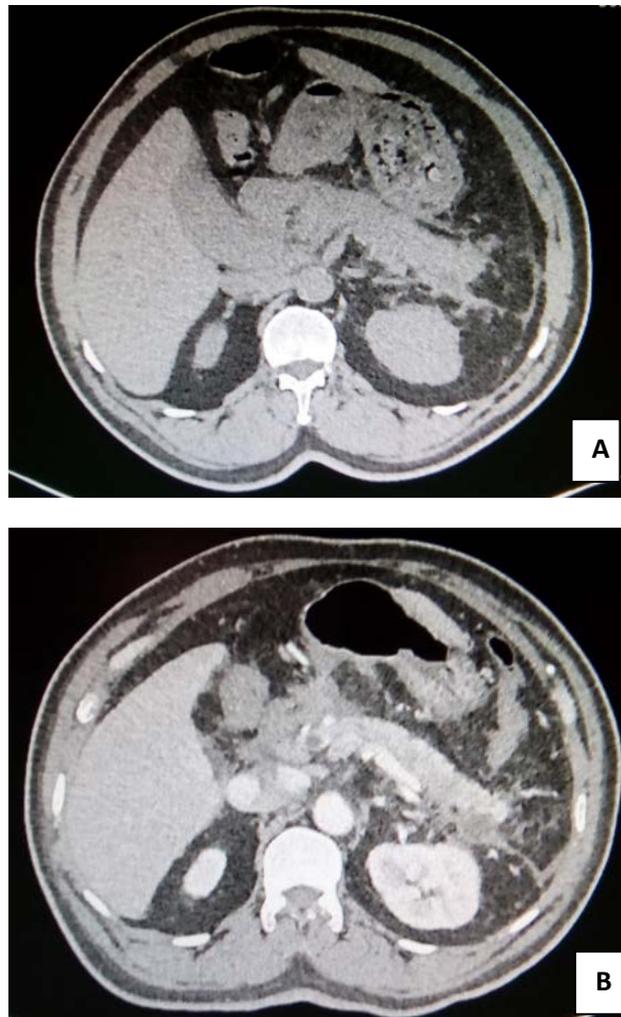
Serial CT scan of the abdomen done on prior hospitalizations. A. Plain CT Scan of the abdomen showing peripancreatic fat stranding along the length of the pancreas. The pancreatic head and uncinata process appear congested and peripancreatic fluid collections or pseudocysts were noted. Also noted with hydrops of the gallbladder with mild dilatation of the proximal intrahepatic duct not appreciated here. B. Repeat CT scan of the abdomen with contrast taken 1 month later showing dilated intrahepatic and extrahepatic bile ducts but no calcified CBD stone seen. Pancreatic fluid collection at the dorsal aspect of the tail of the pancreas still noted and the post-contrast study showed an area of decreased enhancement at the same area representing either an inflammation or a vascular infarction.
